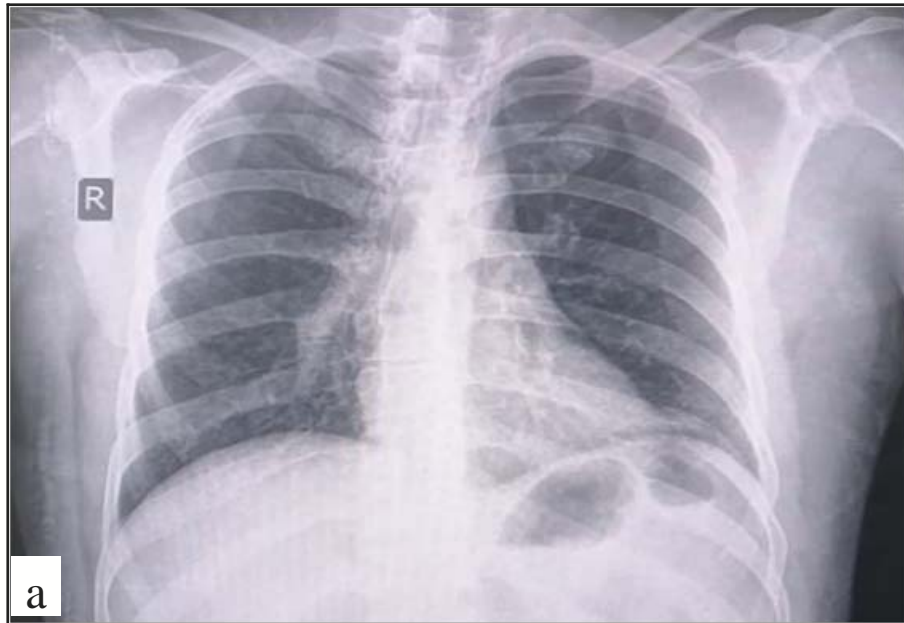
(a) Chest X-ray PA view of a middle-aged male patient with FFH presented with tenderness over the right lower anterior chest wall shows normal X-ray, (b) Ultrasound examination of the same patient showing anterior cortical disruption with a small hematoma, (c) CT scan of the same patient confirmed anterior cortical disruption
